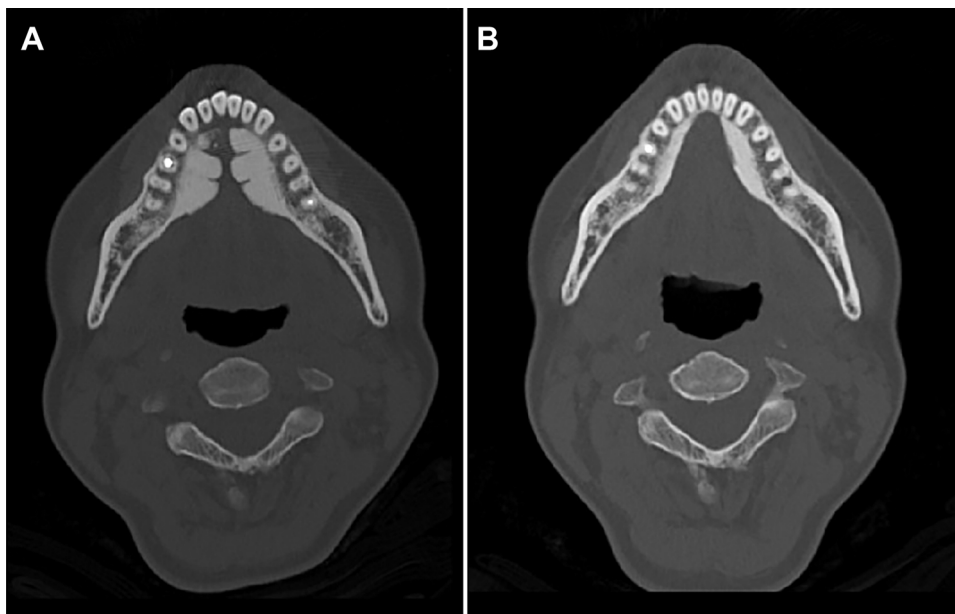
Axial CT images of the bilateral torus mandibularis and airway. (A) Preoperative. (B) Eighteen months postoperative.
